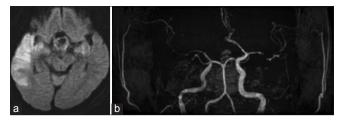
(a) Magnetic resonance imaging indicating extensive infarction at the right middle cerebral artery territory. (b) Magnetic resonance angiography shows poor visualization of both middle cerebral arteries.
